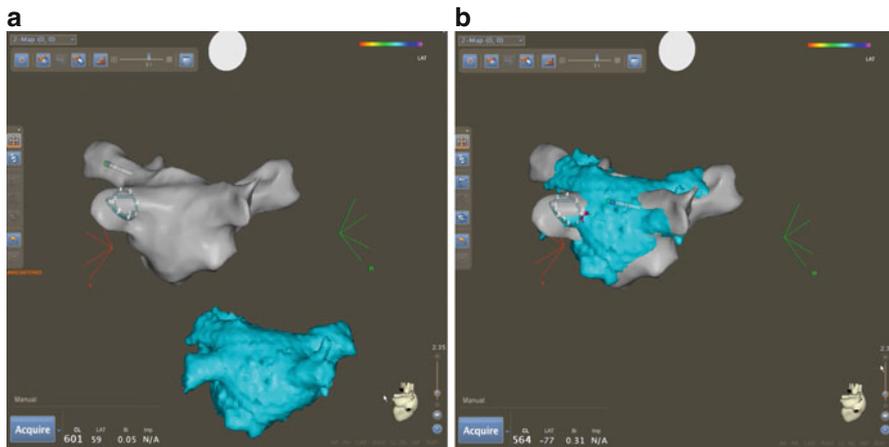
Fast Anatomic Map created using the Lasso Catheter with a CT LA in the *top image*. Landmarks are selected on both the map and the CT and the images are merged as shown in the *bottom image*. (© Biosense Webster, Inc)
